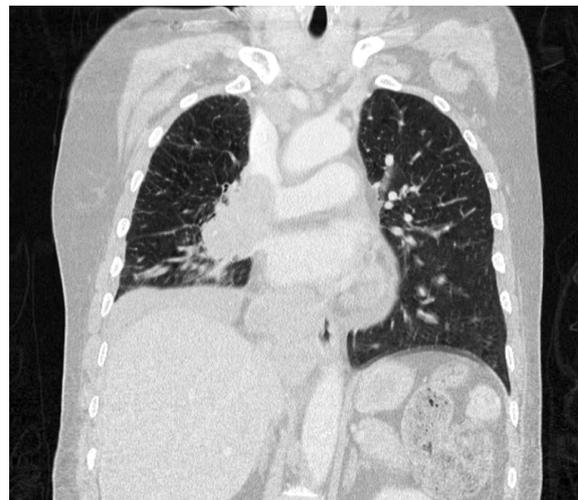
Coronal slice using computed tomography demonstrating right lower lobe mass, with prominent hilar and mediastinal lymphadenopathy, consistent with small cell carcinoma of the lung.
